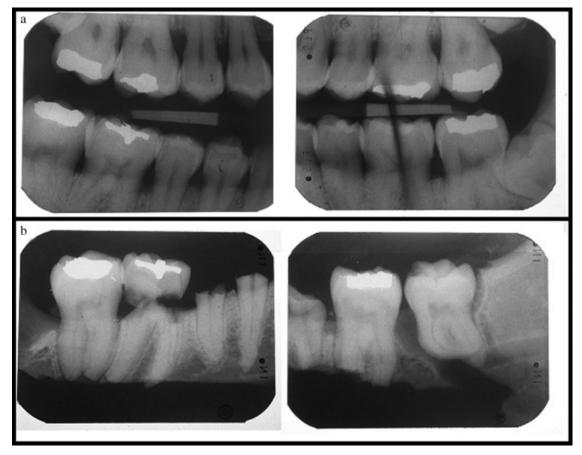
Case IRM 058. (a) Antemortem bitewing radiographs. (b) Postmortem lower bitewing radiographs. The detailed comparison of the shape of the dental restorations to postmortem radiographs allows for a positive identification.
